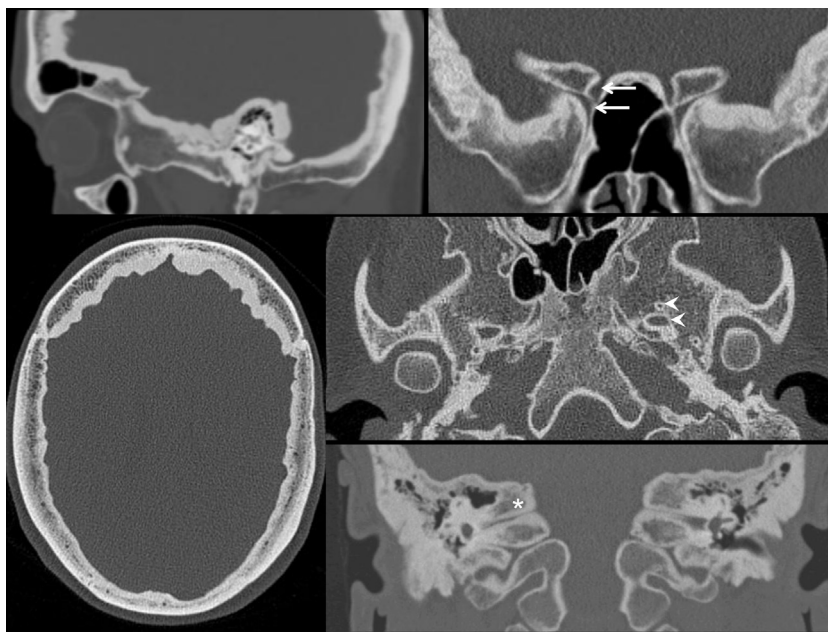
Multiple CT images of patients affected with hyperostosis cranialis interna. Upper left: sagittal image of the skull base and calvaria at the level of the inner ear. An hyperostotic endosteal layer can be seen (female mid-thirties). Lower left: axial image of a markedly thickened skull. Upper right: coronal image (23-year-old female) of the greater and lesser sphenoid wings. Note narrowing of the optic canal (upper arrow) and the superior orbital fissure (lower arrow). Middle right: axial image showing the foramen rotundum (upper arrowhead) and the foramen ovale (lower arrowhead) in an 18-year-old female. Lower right: bilateral narrowing of the internal auditory canal in a 16-year-old patient (asterisk, coronal reconstruction).
